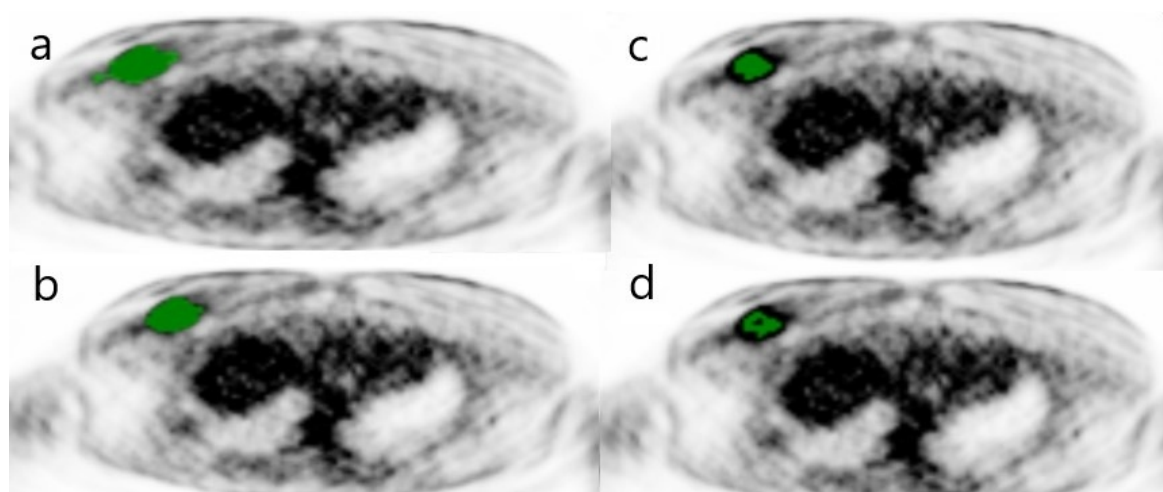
Shows the metabolic tumor volumes obtained from the same patient using different SUV thresholds. a, MTV 2.0; b, MTV 2.5; c, MTV 42%; d, MTV 50%.
